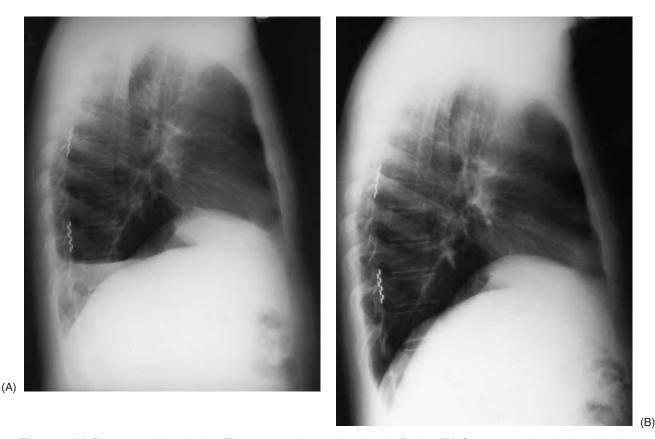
(A) Chest x-ray, lateral view. The arrow points to the pleural effusion. (B) Chest x-ray, lateral view after the resolution of the pleural effusion.
